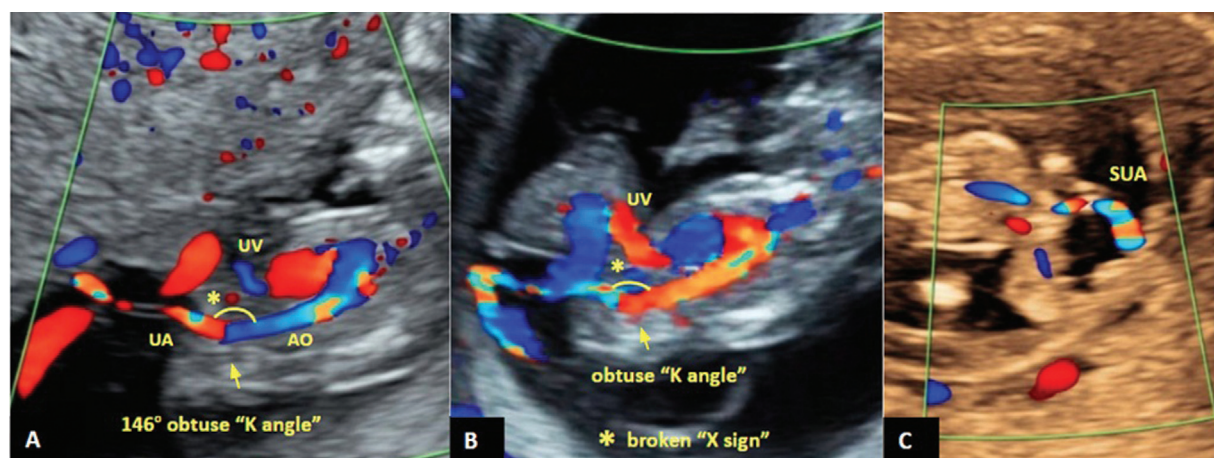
Case 1 at 11 weeks—(A and B) Color Doppler shows altered intrafetal course of umbilical artery (UA), obtuse “K angle,” broken “X-sign” (*), distorted equilateral triangle formed by aorta (AO), UA, umbilical vein (UV) (C) Transverse-pelvic view shows a divergent single-umbilical artery (SUA).
